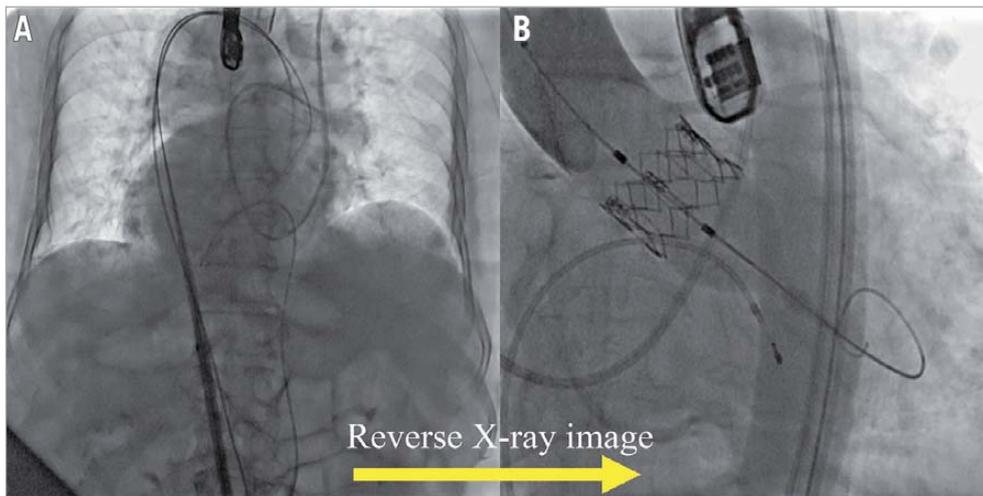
X-ray image. A) Sheath insertion using a normal X-ray image. B) Deployment of a 26 mm Edwards SAPIEN XT valve using the reverse X-ray image.
